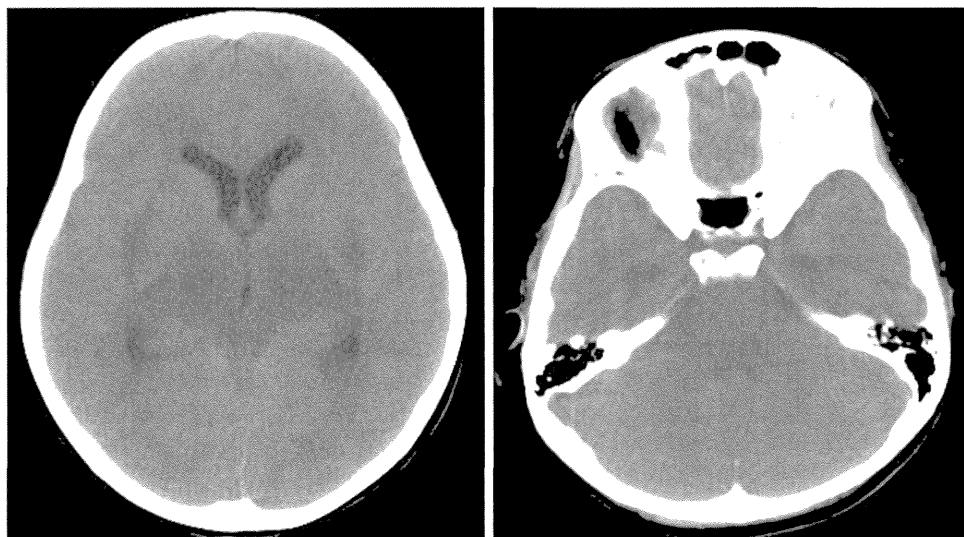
Acute encephalopathy in an 8-year-old girl with STEC O157 infection (Cranial CT). Diffuse brain edema, together with low density and swelling of the bilateral thalami, putamina, external capsules and pontine tegmentum, can be seen
